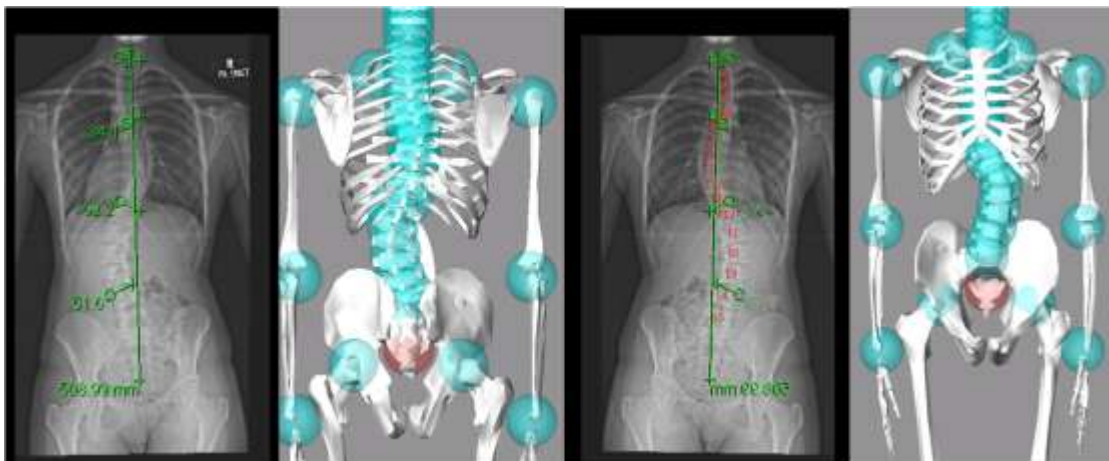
The front and back view of X-ray images and 3D model of P3
